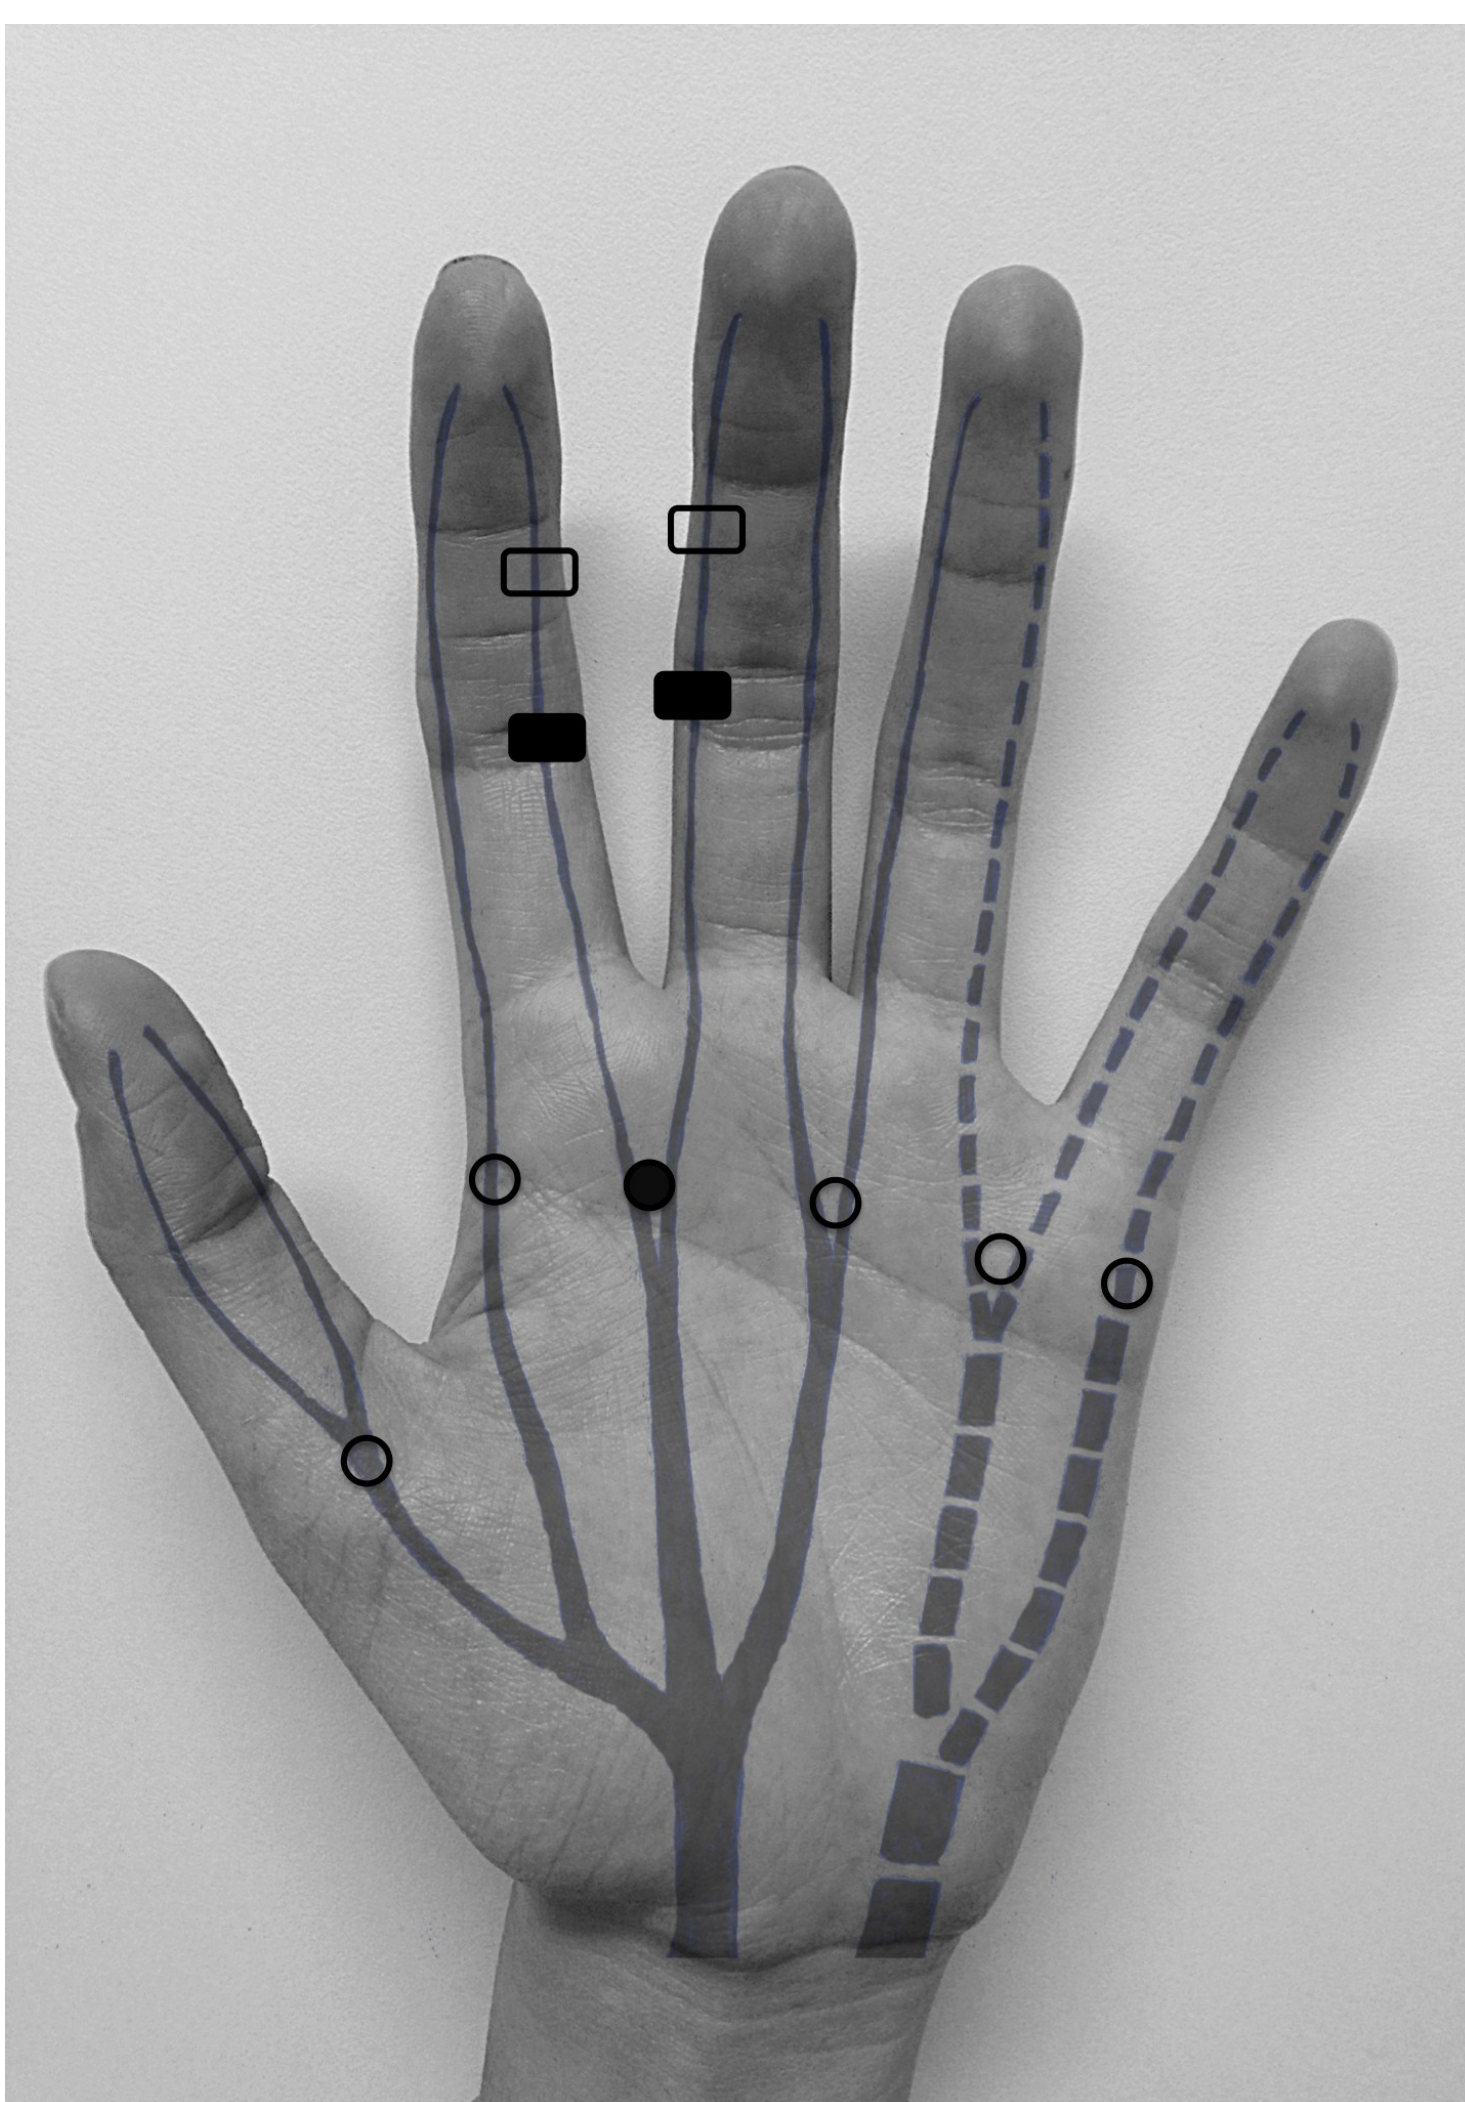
The open/closed circles show the position of the stimulating needle cathode, according to the hand palmar creases. The anatomy of the median and ulnar nerve hand sensory branches, which was verified by ultrasound in a normal subject, is shown in gray and superimposed on the hand. The stimulating cathode was placed on the palmar side of the hand in the webspace, and the reference anode was placed on the dorsal side of the hand in the space between two adjacent metacarpophalangeal joints in correspondence to the cathode. The closed circle shows the position of the cathode for stimulating the second PDMN. The rectangles show the position of the electrodes (closed rectangles: active electrodes, open rectangles: reference electrodes) to record SNAPs in the index finger medial PaPDN and the middle finger lateral PaPDN that are the branches of the second PDMN.
